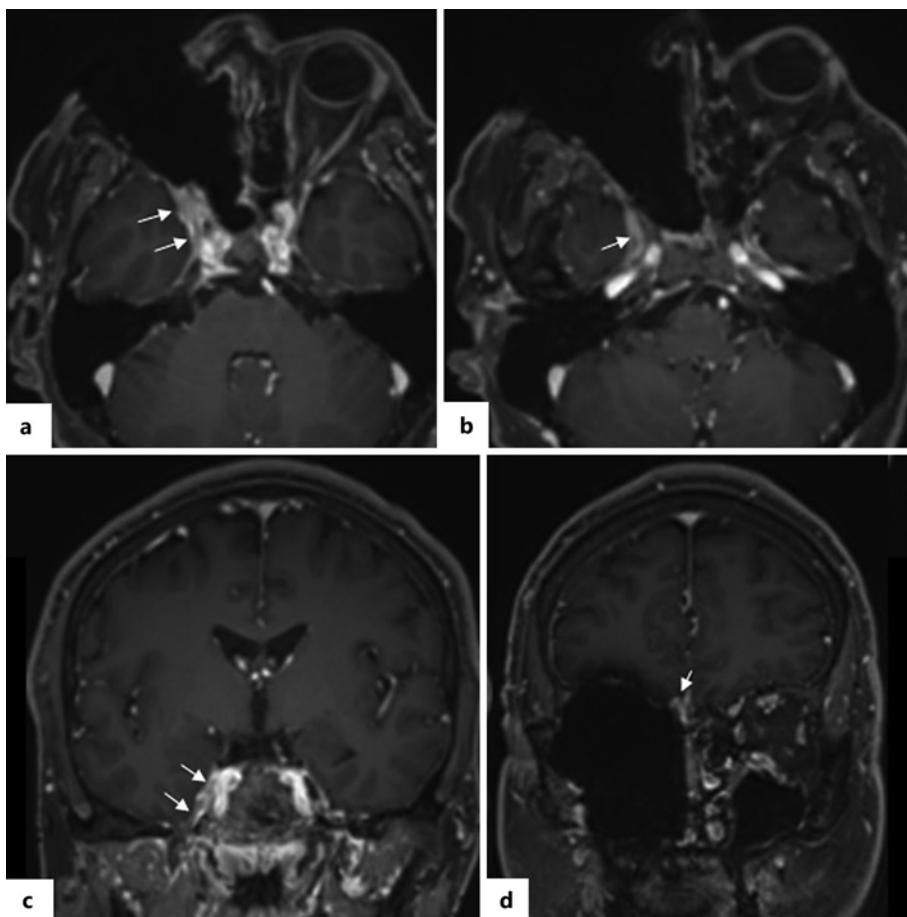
Patient 2: postoperative follow-up MRI after left orbital exenteration. a, b The axial T1-weighted MPR post-contrast shows progression of the inflammation with progressive opacification of the right cavernous sinus (arrows). c The coronal T1-weighted MPR after contrast revealed a perineural extension along the course of the left mandibular nerve on the right side (arrows). d The coronal T1-weighted MPR after contrast shows an avid enhancement of the right frontobasal pachymeninx.
